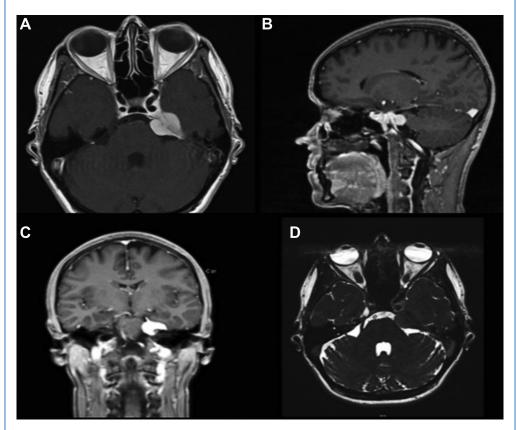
Cranial magnetic resonance imaging showing a homogeneous contrast-enhancing lesion with a dural tail in the petroclival region, with a major component in the posterior fossa – petrous apex area and minor supratentorial extension in the Meckel's cave region. Axial (A), sagittal (B), and coronal (C) T1-weighted contrast-enhanced images. Axial true fast imaging with steady-state precession sequence (D), displaying the relationship of the lesion with the nervous and vascular structures.
